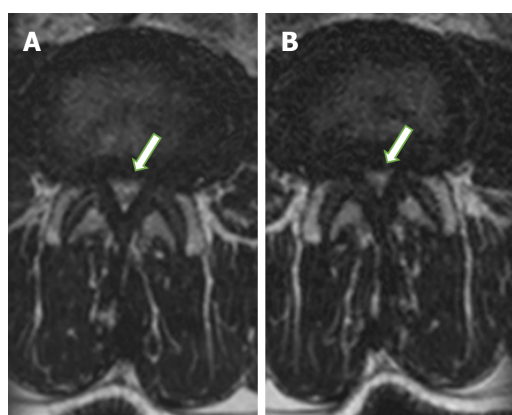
Transverse magnetic resonance imaging. A: Recumbent T2-weighted images. The rootlets occupy the whole of the dural sac (arrow), but they can still be individualized; B: Spinal stenosis with a reduction in the dural sac size after axial loading. No rootlets can be recognized, but some cerebrospinal fluid is still present, giving a grainy appearance to the sac (arrow).
